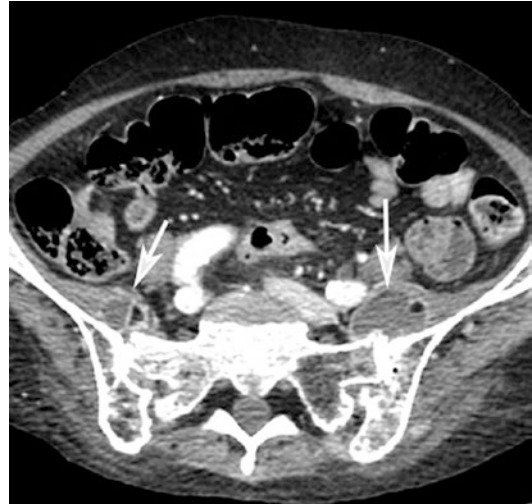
Post-contrast CT axial scan of the pelvis shows bilateral iliopsoas muscle small fluid collections surrounded by a thin hyperdense capsule (*arrows*) corresponding to abscesses
